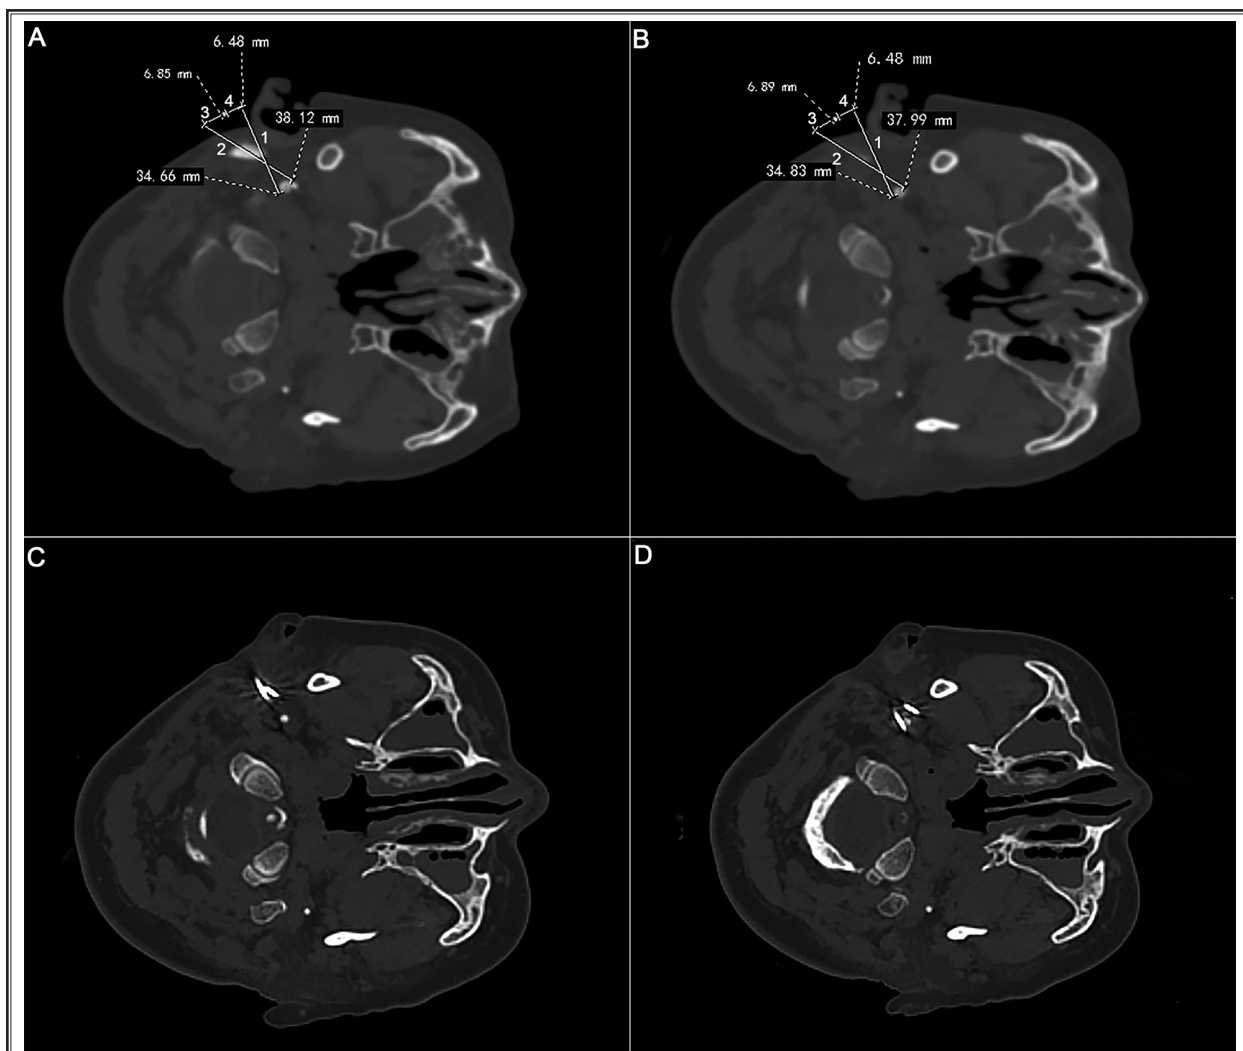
Intraoperative steps for using awake CT-guided double-needle PRT to treat GPN.
